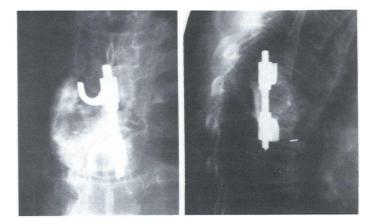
Postoperative anteroposterior radiograph demonstrating the fusion construct (left); postoperative lateral radiograph demonstrating the fusion construct (right).
